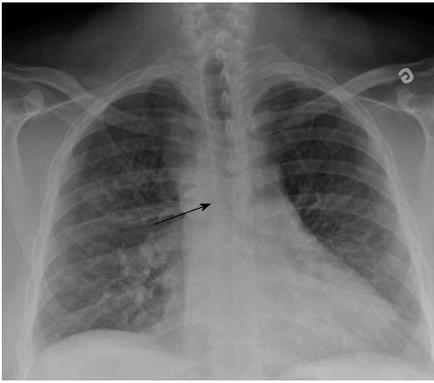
Chest X-ray scan showing the right aortic knob and arch as well as slight shift of the inferior trachea to the left (arrow).
